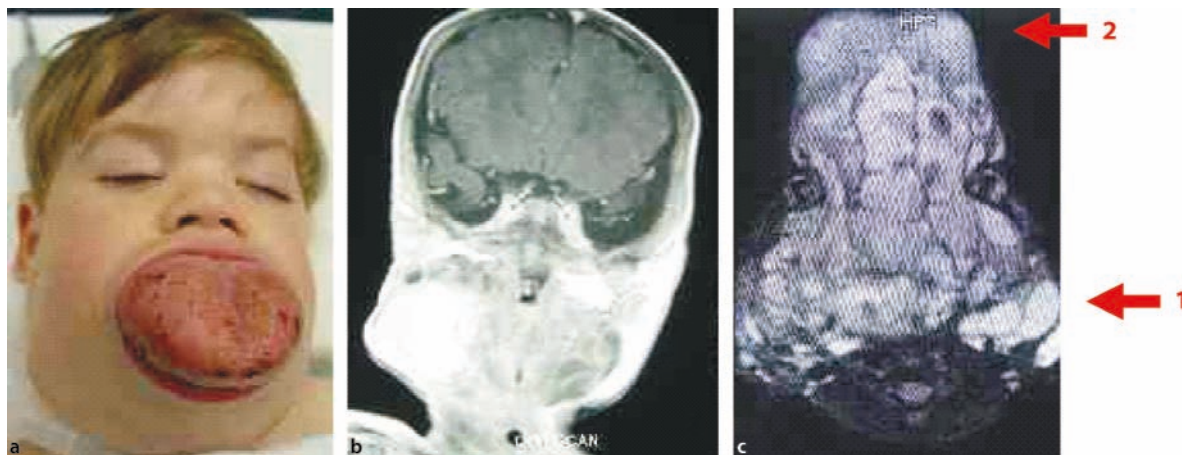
Patient with extensive cervicofacial lymphatic malformation and macroglossia (a), with MRI (b, c) showing micro (1) and macrocystic (2) areas
